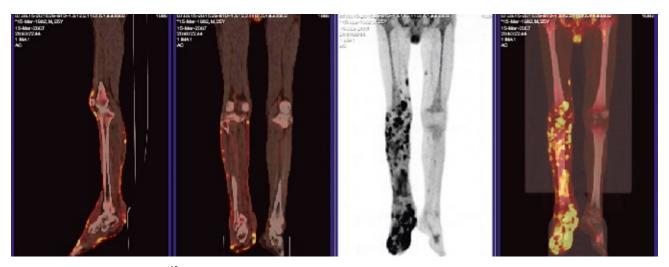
Increased ¹⁸F-FDG uptake with cutaneous and subcutaneous hypermetabolic lesions on the right leg zones.
